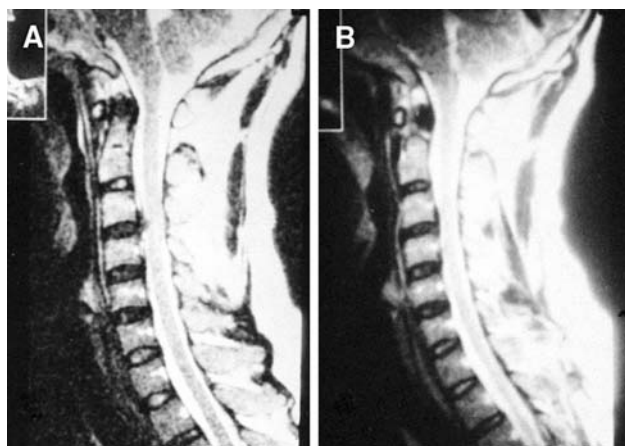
Preoperative MRI reveals a bulging herniated disc at C3–4 (a) and 6 months post operation of PCN showed the bulging disc had disappeared (b)
